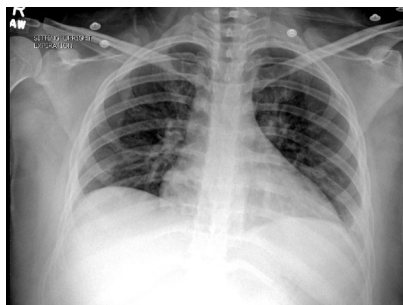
Chest X-Ray showing left perihilar opacities.
